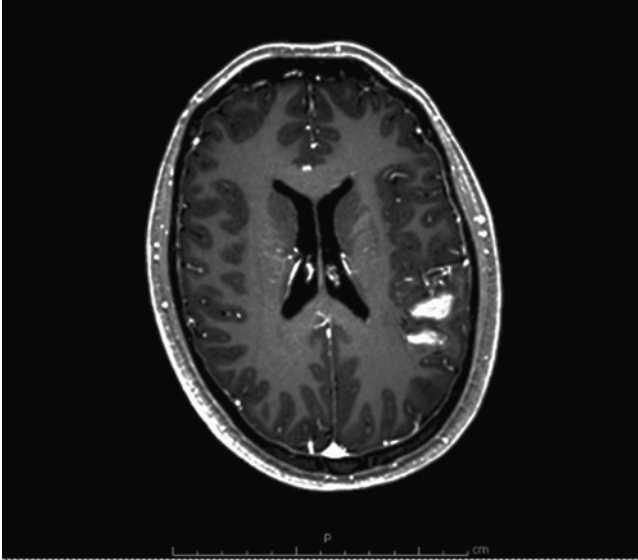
Axial T1 MRI of the brain with gadolinium demonstrating a ruptured left frontoparietal AVM with associated hematoma
